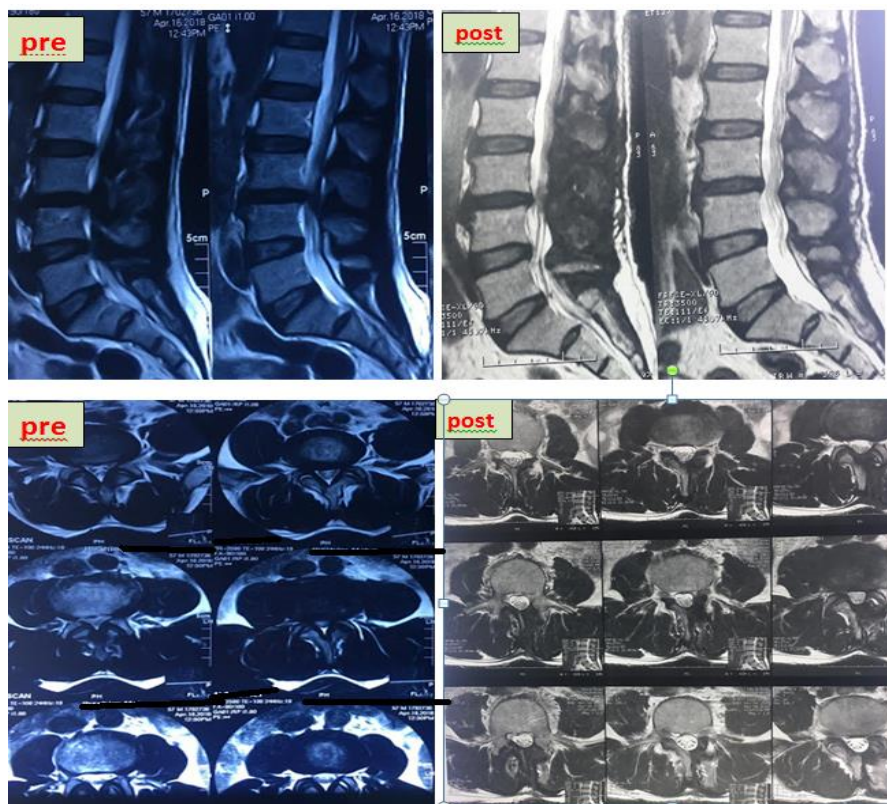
MRI LSS sagittal & axial cuts, preoperative images (pre): Showing LCS at L2-3-4, postoperative images (post): showing well decompressed L2-3-4 levels.
